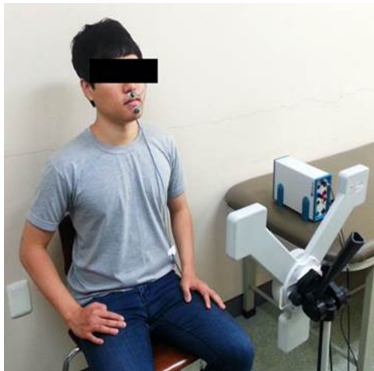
Measurement of the temporomandibular joint motion using a 3D ultrasound-based motion analysis system. Two single-active markers were attached on the upper jaw (philtrum) and midpoint of under jaw.
